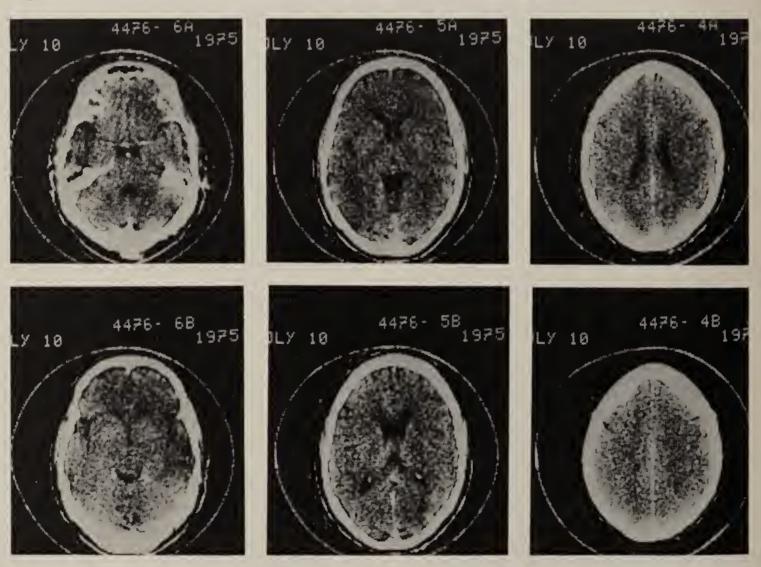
Normal computed tomogram (C.T.). The lowest "slice" is 1A; the highest is 3B. The right side of the head is on the reader's right.
